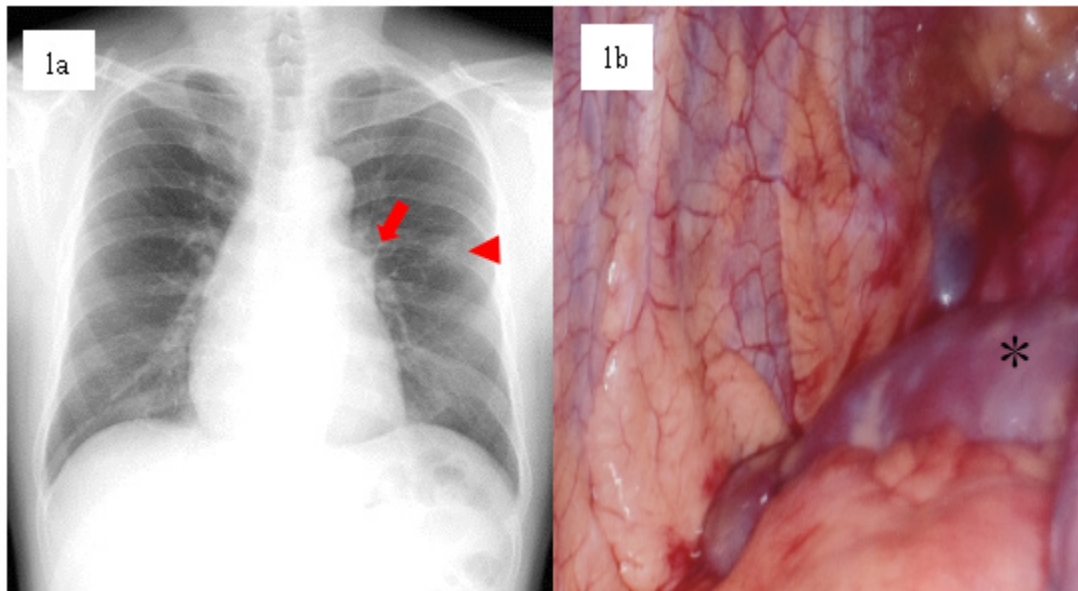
Chest X-ray shows a bulge of the left upper heart border (arrow) and ground-glass nodule (GGN; arrowhead). Naked atrium was observed during surgery (asterisk).
